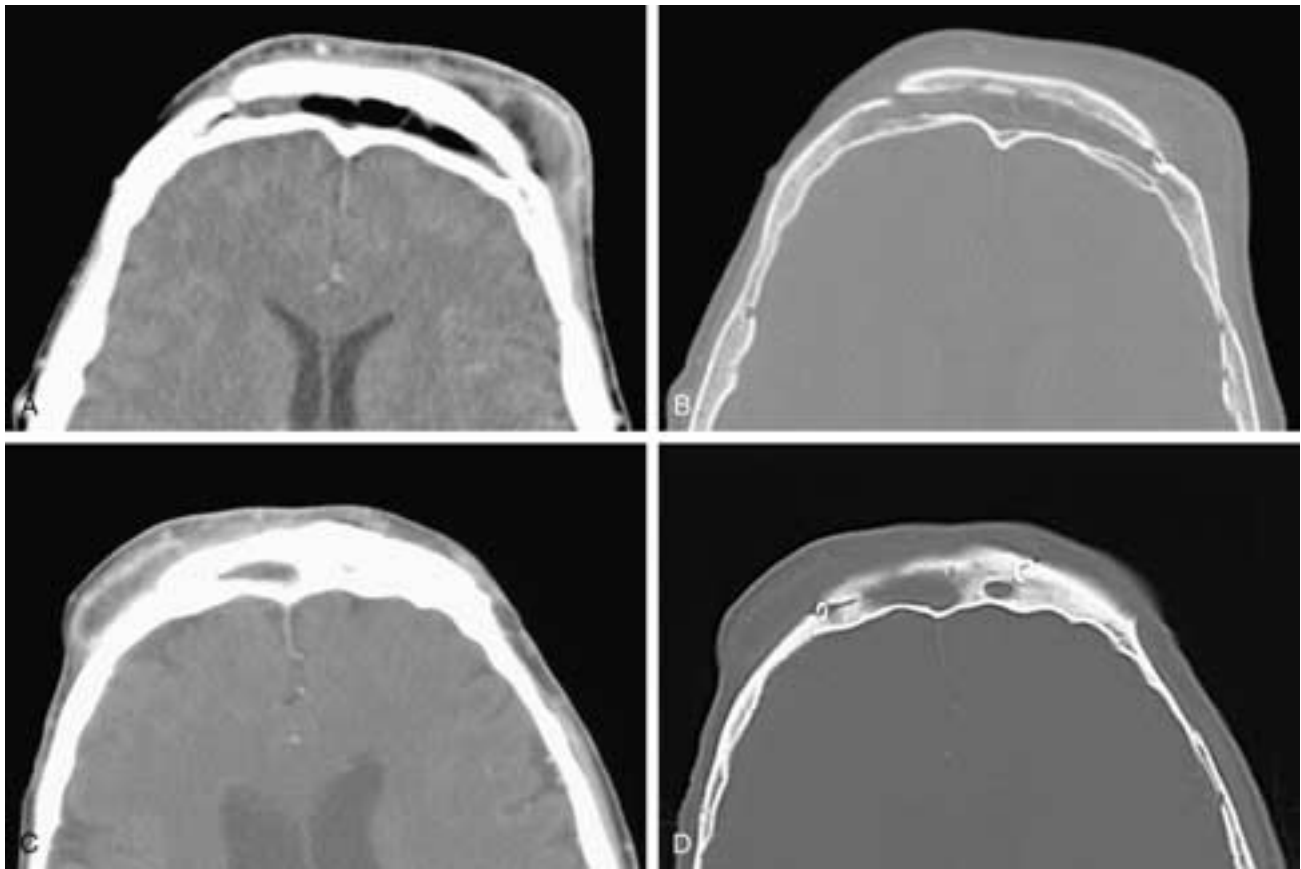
Axial CT scans at narrow (A) and wide (B) window settings. The patient has had an osteoplastic flap procedure. Despite the presence of primarily fat attenuation within the sinus, the right side of the bone flap is elevated, there is an abscess at the left margin of the flap, and there is swelling of the forehead soft tissues. This was an infected flap. Axial CT scans at narrow (C) and wide (D) window settings on another patient. In (C), an abscess is seen in the forehead soft tissues. Although it lies at the right margin of an osteoplastic flap, the bony flap cannot be seen clearly. In (D), the bony flap is clearly seen. This was an early abscess, developing after local head trauma to the region. The flap is otherwise normal on imaging.
